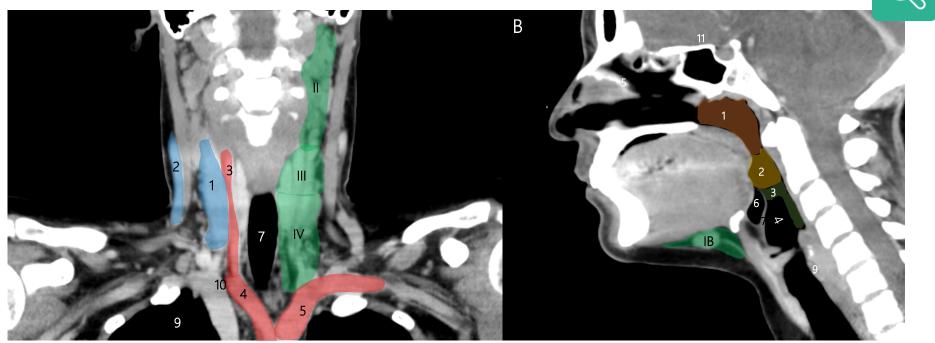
Coronal and sagittal reformatted CT images. Mainly due to the complexity of cervical anatomy, sagittal und coronal reconstructions are important to the reading radiologist. The coronal reconstruction (A) offers an overview over the cervical blood vessels and the lymph node level II-IV. In the sagittal reconstruction (B) the different regions of the pharynx and the laryngeal structures can be evaluated more efficiently. Additionally a submandibular lymph node is displayed (level IB).
